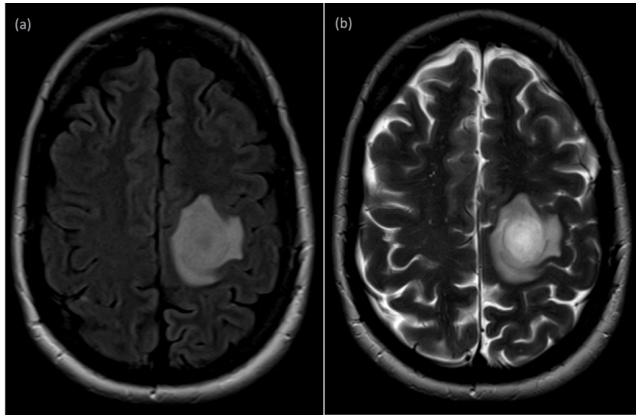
FLAIR (a) and T2- WI (b) depicting a hyperintense lesion with a hypointense rim in the respective area of enhancement and limited perilesional oedema.
